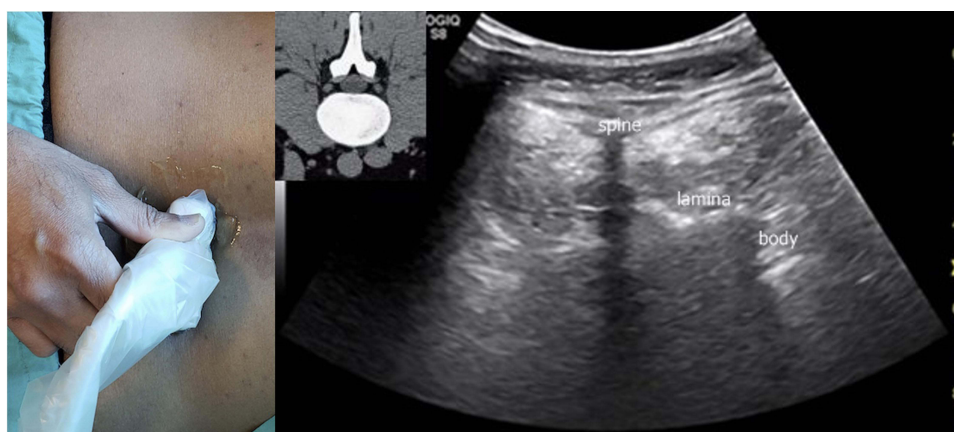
Oblique transverse plane view. The probe position was used to obtain sonographic lumbar spinal anatomic view as outlined. The CT anatomy is also shown for correlation.
